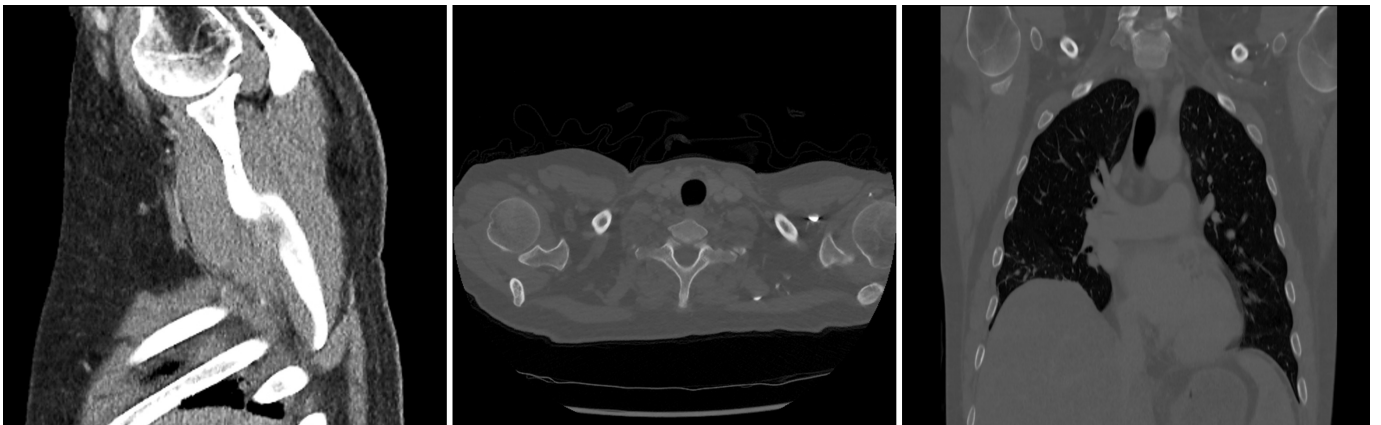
CT body scan (Bone windows) taken 3 months prior to the onset of symptoms. This includes the left humeral head and demonstrates no obvious signs of AVN at the time of the scan. From left to right; Sagittal slice, Axial slice, Coronal Slice.
